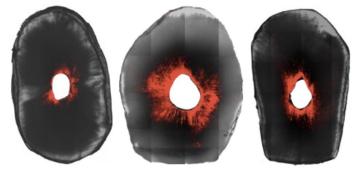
Representative figures from left to right: Control group, XP-endo Finisher® group and Ultrasonic irrigation group.
